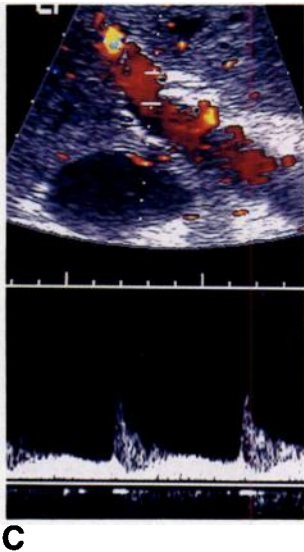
Comparison of Doppler shifts from two cavernomas with those from normal portal vein.
